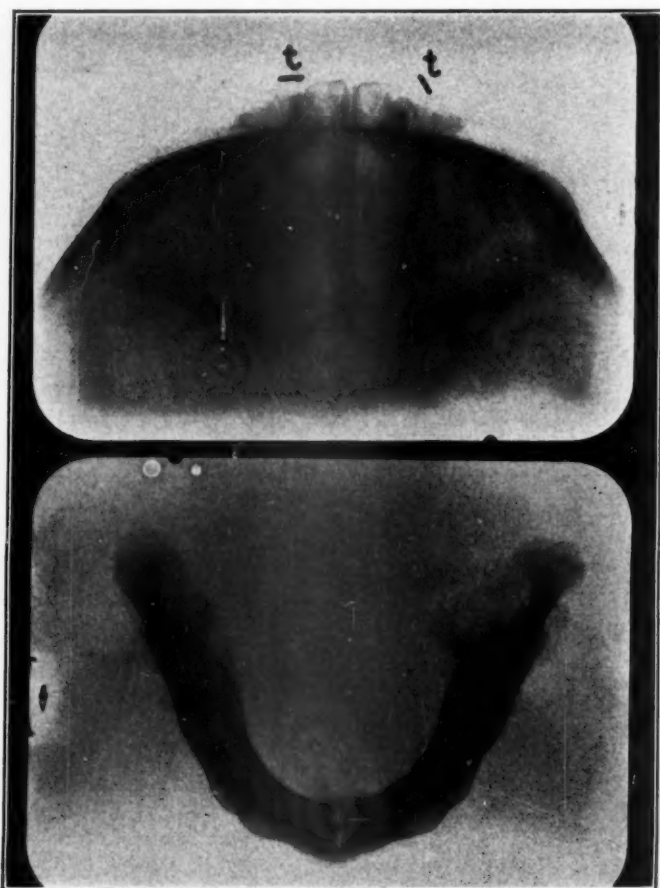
Occlusal x-ray picture of a stillborn infant, showing variation of position of the maxillary second deciduous incisors. There is symmetry of position in the mandibular incisors but asymmetry of position in the maxillary second incisors, one being rotated.
